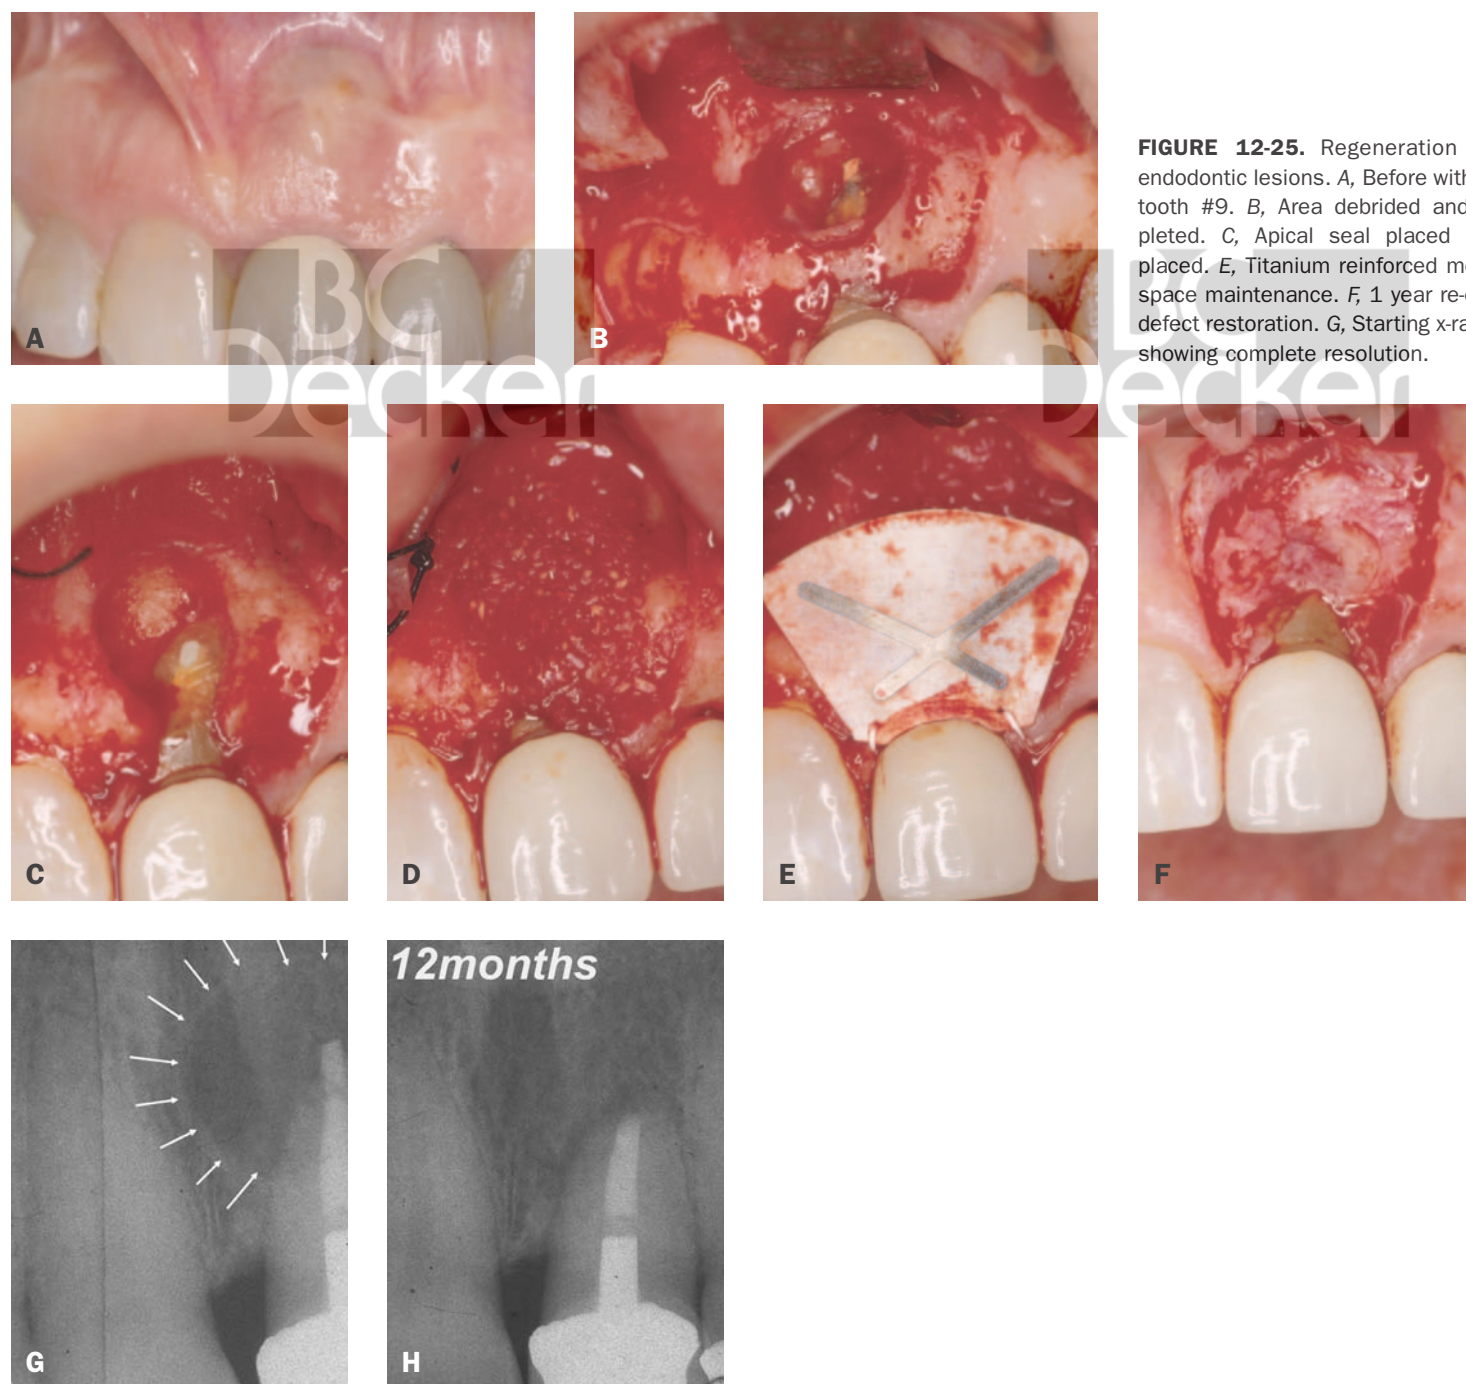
Regeneration for treatment of endodontic lesions. A, Before with large swelling over tooth #9. B, Area debrided and endodontics completed. C, Apical seal placed in root. D, DFDBA placed. E, Titanium reinforced membrane placed for space maintenance. F, 1 year re-entry with complete defect restoration. G, Starting x-ray. H, 12-month x-ray showing complete resolution.
